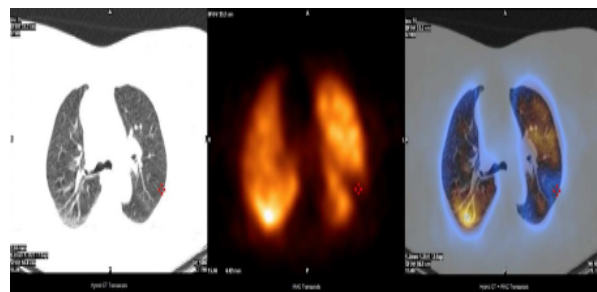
SPECT/CT study with ^{99m}Tc -MAA. Perfusion defect of left lung superior segment seen on transverse slices and corresponding normal density in SPECT/CT lung scintigraphy hybrid imaging: images from left-lung CT, lung perfusion study, lung fusion image. Department of Nuclear Medicine, Pomeranian Medical University, Szczecin
